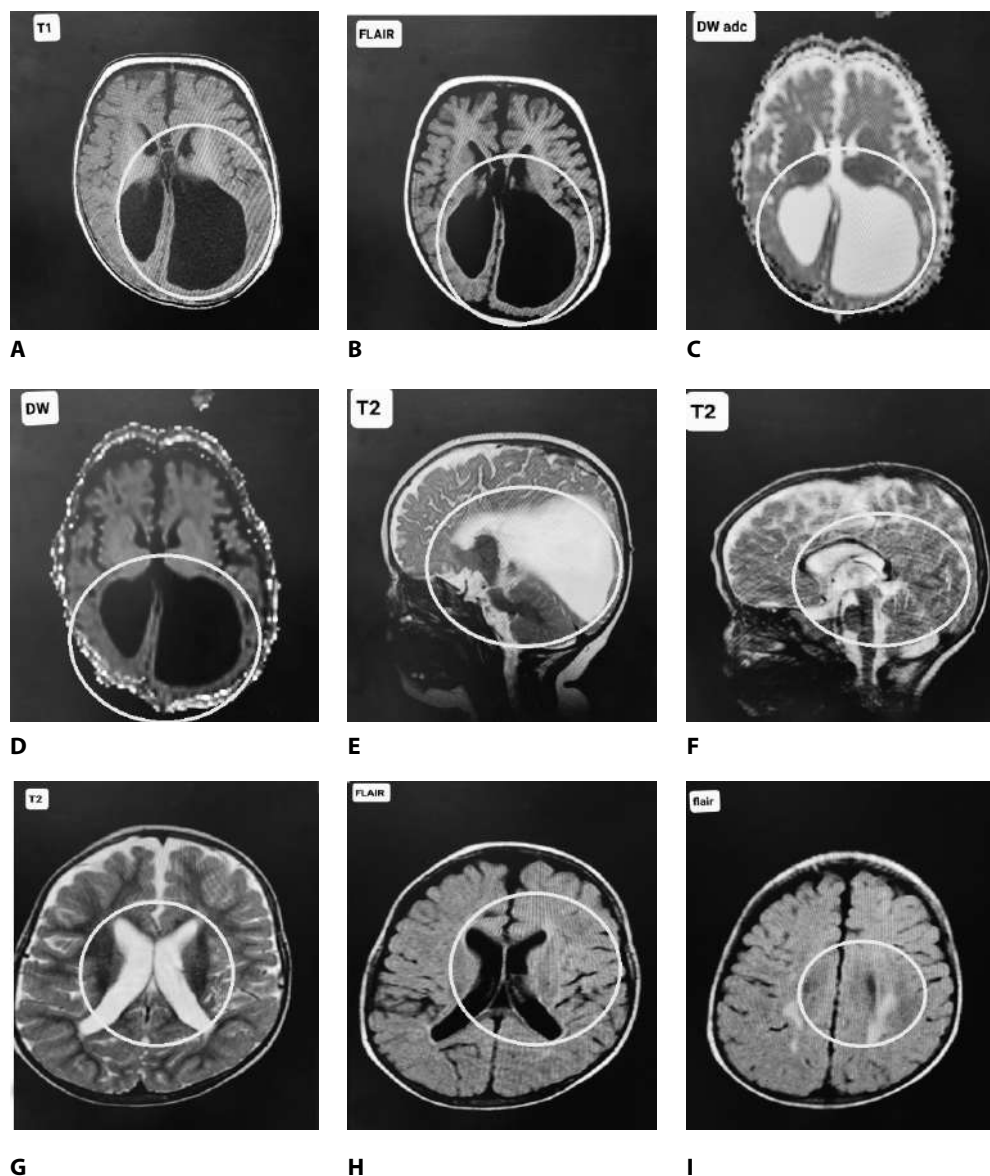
8 months female (Corpus callosum agenesis and cerebral atrophy): A. T1WI axial and B. FLAIR axial: hugely dilated posterior horns of lateral ventricles mostly left side. C. ADC: (DW): normal diffusion. D. DWI: normal diffusion. E. T2WI: sagittal severe colpocephaly. F. T2WI sagittal: absence of corpus callosum. G. T2WI axial: dilated lateral ventricles with prominent sulci. H. FLAIR axial: fluid signal drop
